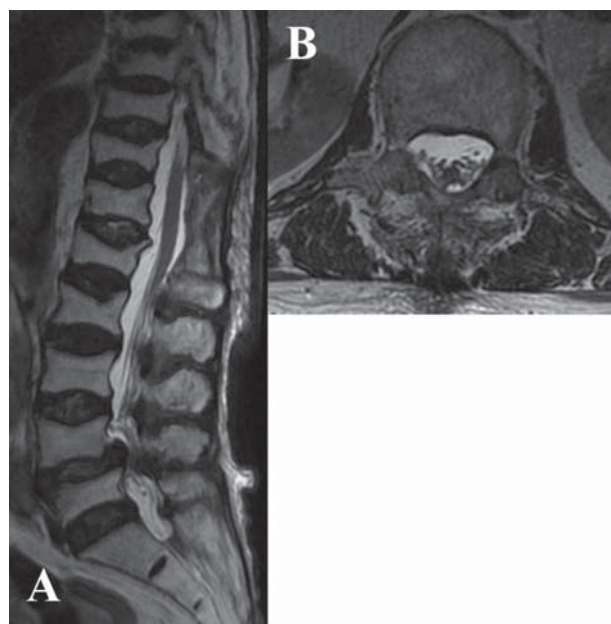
Follow-up MRI study showing disappearance of the SEDH with no signal change in the spinal cord
